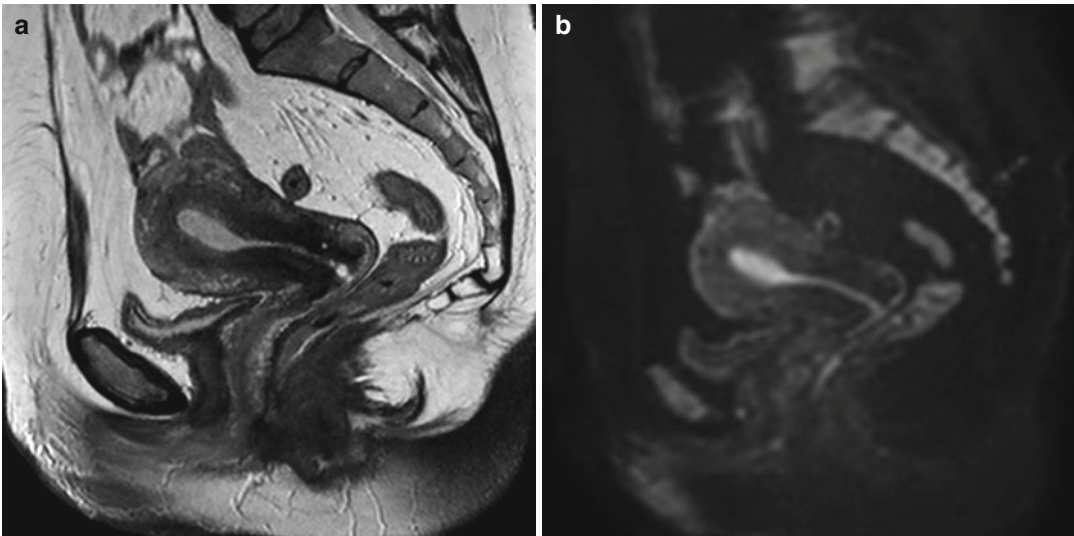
Sagittal T2-weighted (TR 3,250 ms, TE 80 ms) (a) and sagittal DWI with b -Factor 800 ms (TR 4,000 ms, TE 75 ms) (b) of a normal uterus. We can see very well the distinction between the endometrium, which has low
